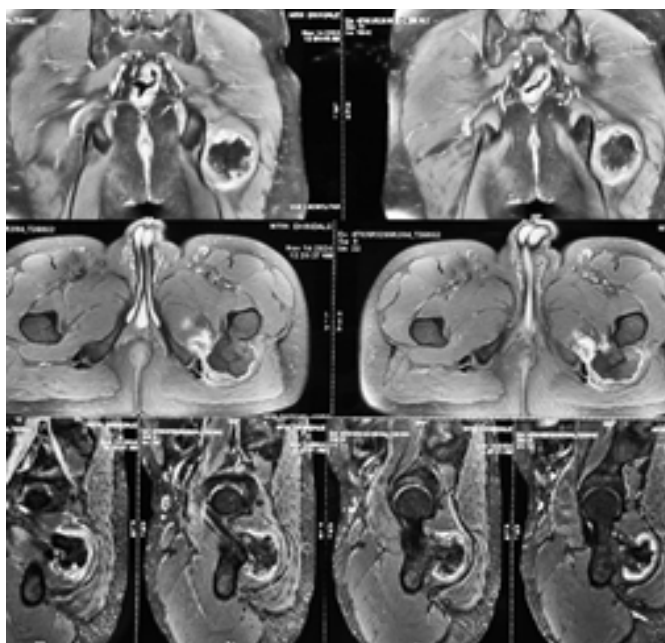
Magnetic resonance imaging scans indicate a hypointense lesion in the proximal femur.
